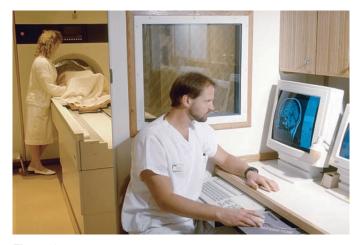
MRI laboratory. Will and Deni McIntyre/Photo Researchers, Inc.
